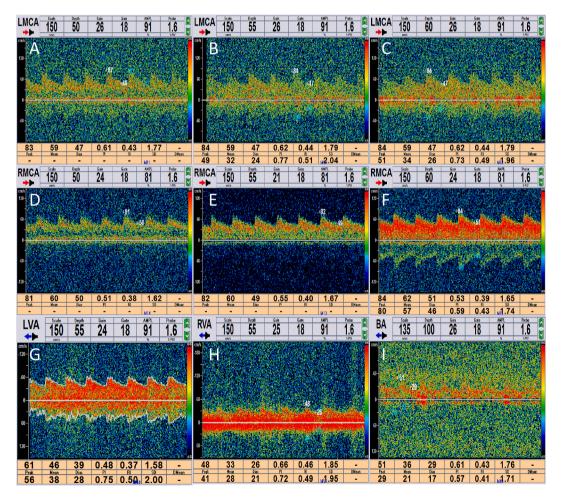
On the 5th day after the operation, transcranial Doppler ultrasonography showed that the blood flow velocity of the right middle cerebral artery fluctuated from 81 to 84 cm/s (4D, E and F), which was basically symmetrical with the blood flow velocity of the left middle cerebral artery (4A, B and C), and the blood flow velocity, PI value and RI value of all cerebral vessels were in the normal range (4A-I).
